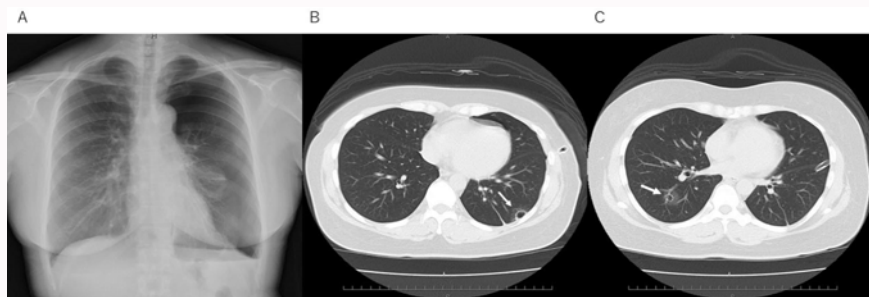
A) Chest radiograph showing a pneumothorax on the left lung. Axial chest computed tomography scan of lower lobes showing two well-defined lung cysts present. The cyst walls are smooth and thin. B) The left one is in a sub pleural location (black arrow). C) The right one is located centrally (white arrow).
